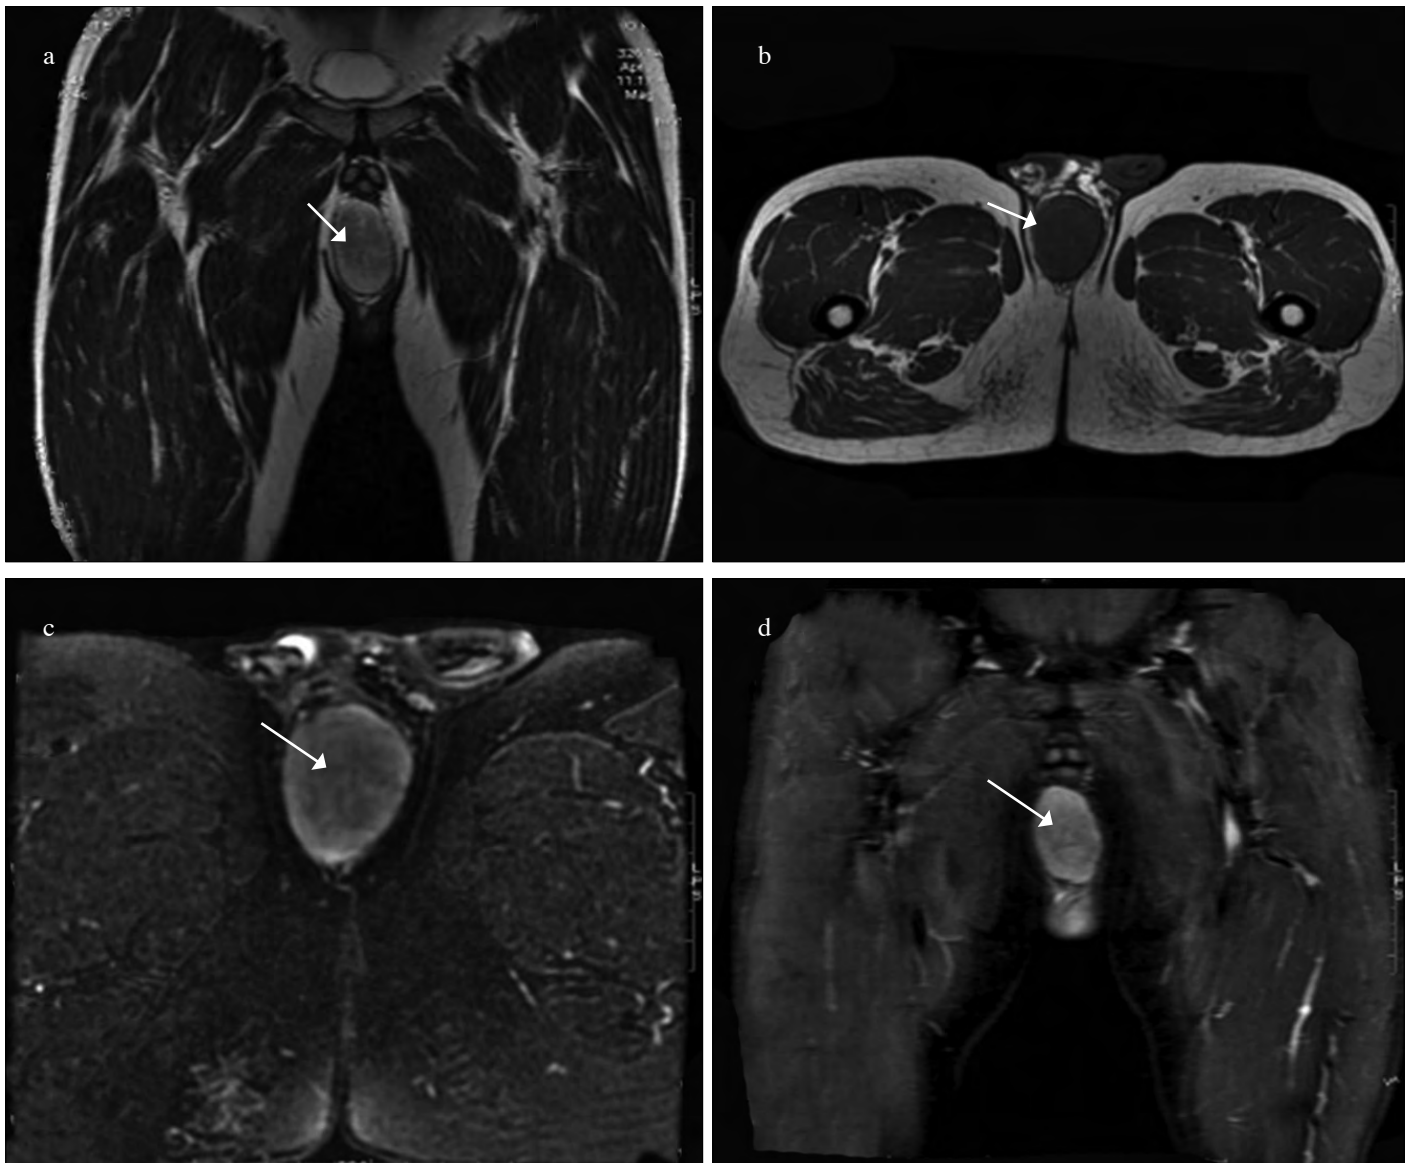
a-d. Magnetic resonance imaging (MRI) findings: (a) T2-weighted image showing a well circumscribed, high- intensity signal lesion in the right scrotal area. (b) T1-weighted image showing low- intensity signal lesion in the scrotal area. (c) Fat suppression image showing fat- poor lesion in the scrotal region. (d) There is diffuse enhancement of the lesion on post-contrast MRI
